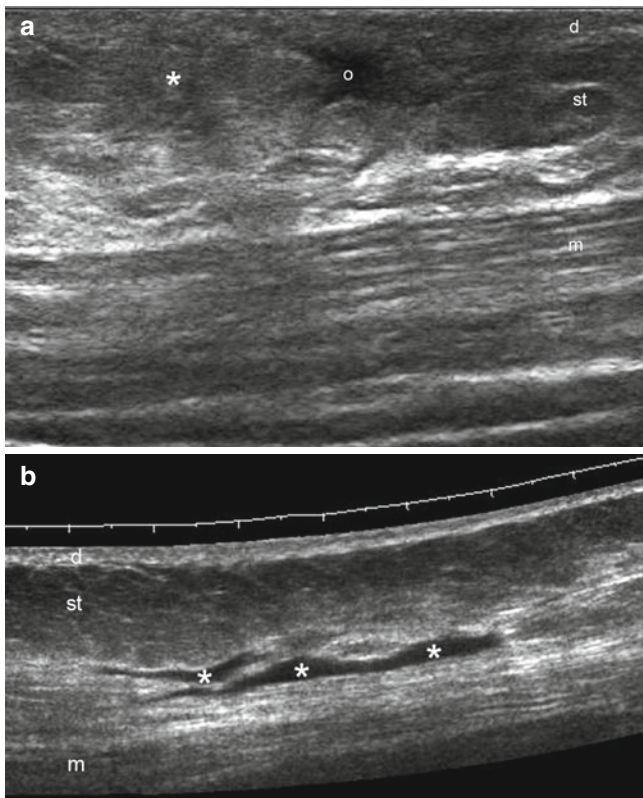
(a, b) Liposuction. (a) Grey scale ultrasound image (longitudinal view) of the left flank of a patient with a history of recent liposuction. Notice the hyperechogenicity (*) of the subcutaneous tissue that lacks fatty lobules and presents a anechoic fluid sero-hematic collection (o). (b) A different case (longitudinal view, right flank) demonstrates anechoic bands of sero-hematic fluid collections (*) in the subcutaneous tissue. *Abbreviations:* *d* dermis, *st* subcutaneous tissue, *m* muscle
